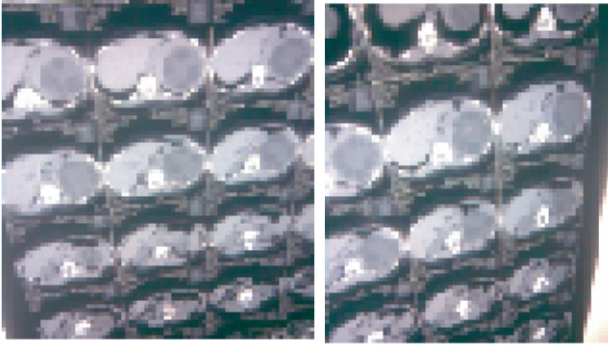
CT scan of abdomen shows splenic hydatid cyst
